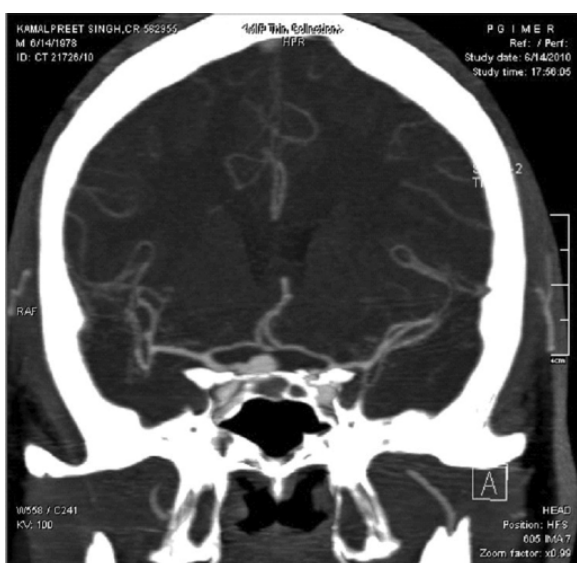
Computed tomography angiography—right superior hypophyseal artery aneurysm
